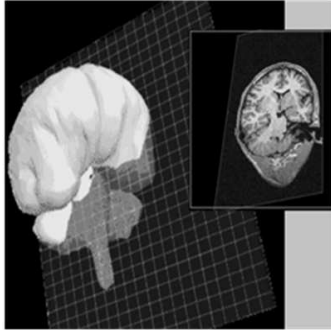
Moveable cutting plane technique from a brain dataset acquired with MRI [13]
